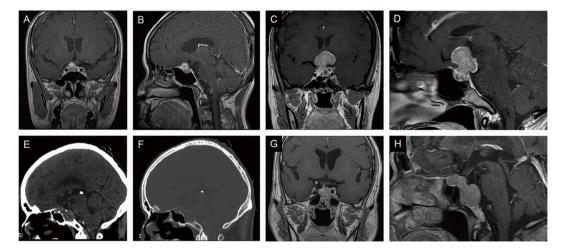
Neuroimaging of pituitary metastasis. Enhanced coronal (A) and sagittal (B) T1 MRI scans of Case 6 reveal abnormal enhanced nodules at the pituitary gland with adjacent parasellar enhancing dura mater. The optic chiasm is compressed upward without apparent sellar base depression. There is no obvious bone destruction. Enhanced coronal (C) and sagittal (D) T1 MRI scan of Case 2 show heterogeneously enhancing intrasellar mass with suprasellar extension in a dumbbell configuration, causing optic chiasmatic compression. Sagittal head CT scans on the soft-tissue window (E) and bone window (F) demonstrate bone destruction of the sellar dorsum and clivus. Enhanced coronal (G) and sagittal (H) T1 MRI scans of Case 7 show a heterogeneously enhanced intrasellar mass involving the left cavernous sinus and clivus. The pituitary stalk deviates to the right.
